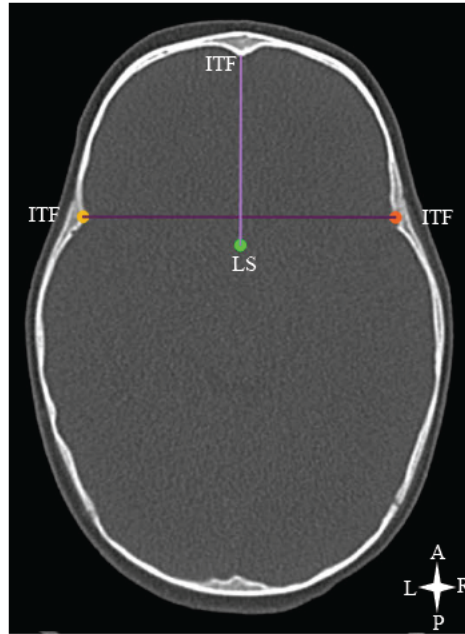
ACF measurements on an axial CT scan of a normal patient (length: LS to ITF; width: ITF to ITF). Key: LS – midpoint of limbus sphenoidale (transcended point); ITF – inner table of frontal bone
